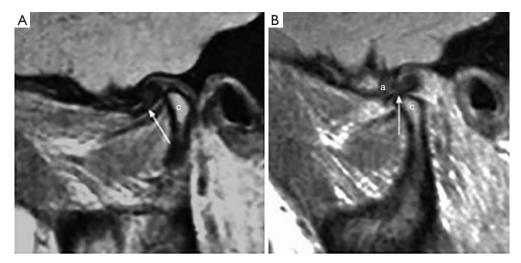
Sagittal magnetic resonance imaging demonstrated anterior displacement of the temporomandibular articular disc with reduction (open access source: Bag AK, Gaddikeri S, Singhal A, *et al.* Imaging of the temporomandibular joint: An update. World J Radiol 2014;6:567-82). (A) Closed-mouth position showing disc (arrow) anteriorly displaced in front of the mandibular condyle (the letter c). (B) Open-mouth position showing reduction of disc (arrow) between articular eminence (the letter a) and the mandibular condyle (the letter c).
